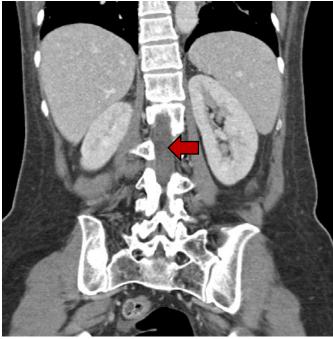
CT Abdomen/Pelvis with contrast. Soft tissue thickening surrounding the SMA suspicious for SMA vasculitis with possible small mycotic pseudoaneurysm component versus intraluminal branching thrombus.
